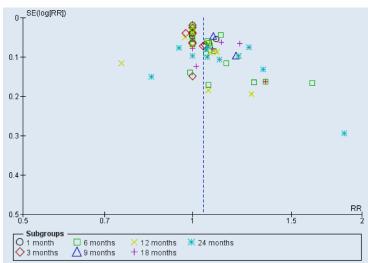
Funnel plot for MTA versus FC — Radiographic outcome.
